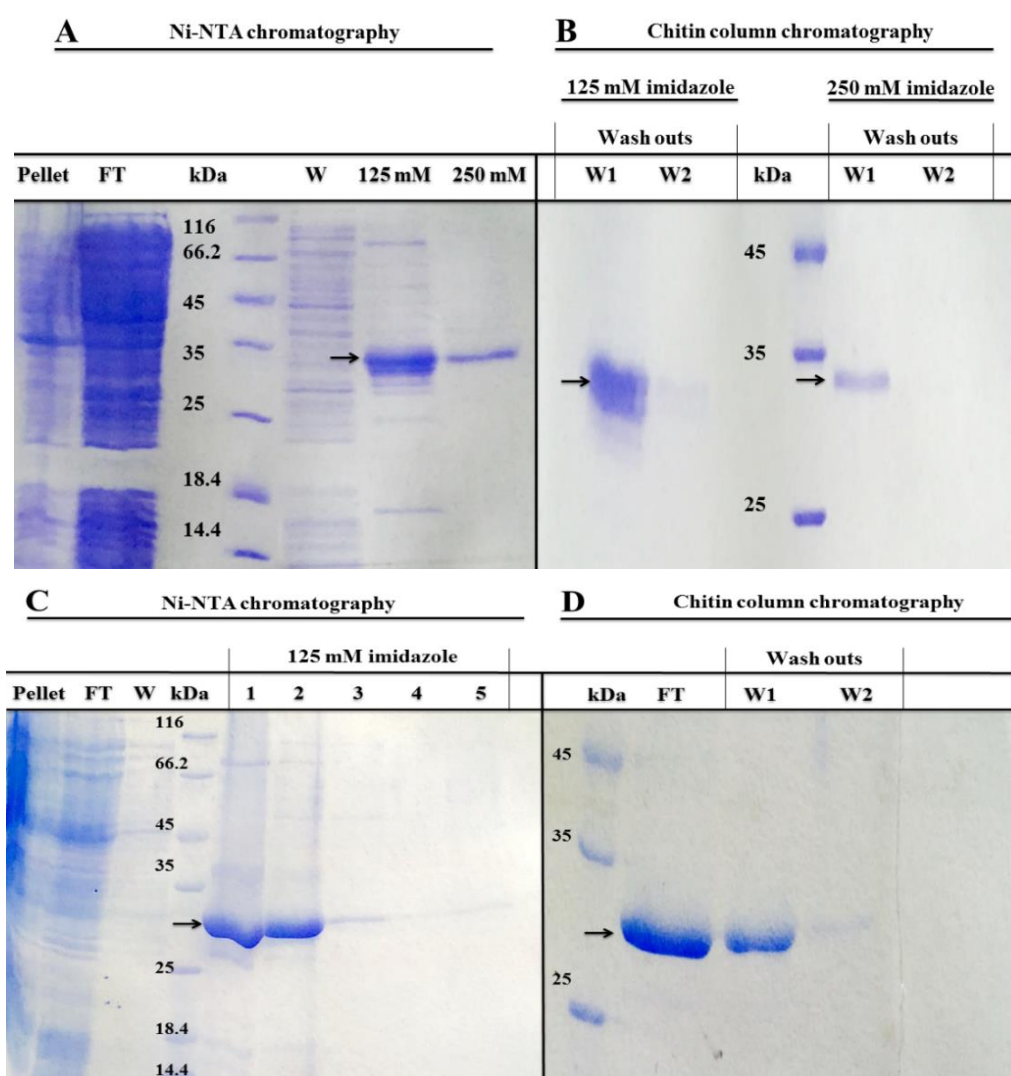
SDS-PAGE (12%) of pellet obtained after ultrasonication and purified fractions of proteins (A, B) DE and (C, D) dianthin obtained after (A, C) Ni-NTA chromatography and (B, D) chitin column affinity chromatography as shown by arrows. FT, flow through; W, W1 and W2, washouts obtained after different elution concentrations. Concentrations (125 mM, 250 mM) indicate imidazole eluates. In (C) 1, 2, 3, 4 and 5 refer to 125 mM imidazole concentration eluates.
